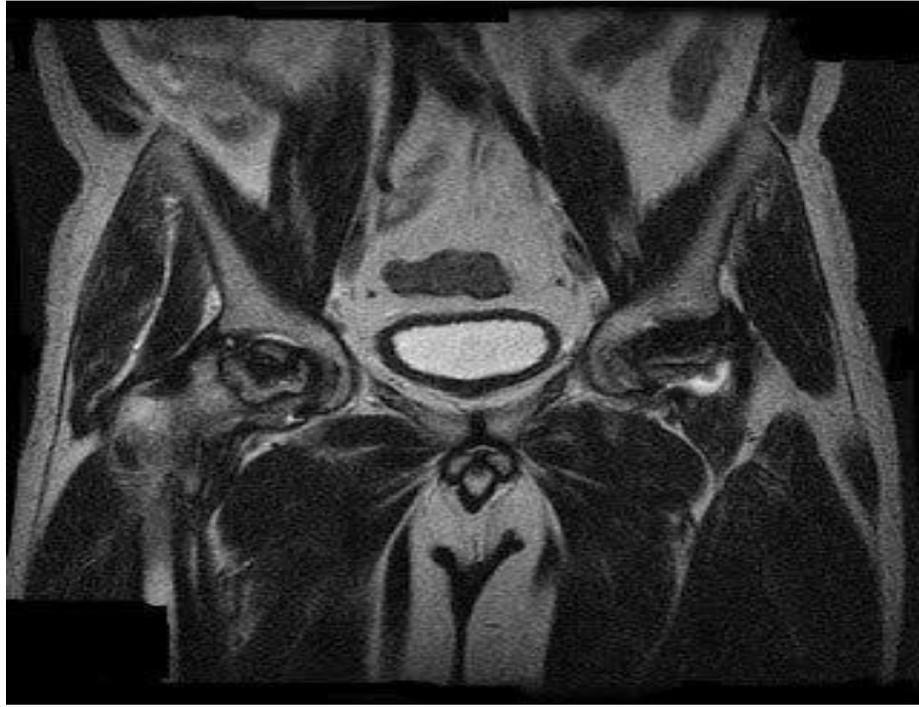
MRI of patient B.A. born in 1958, No. IB 03773/214 with stage IV ANFH .
